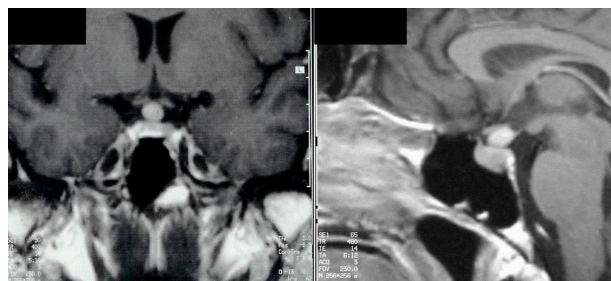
On the left, coronal T1-weighted, contrast-enhanced MR imaging showing a rounded mass located at the level of the pituitary stalk, over the pituitary gland, that appears intact; on the right, sagittal T1-weighted, contrast-enhanced MR imaging confirming the presence of a round mass located at the level of the pituitary stalk, over the pituitary gland, which in this plane seems enlarged in volume.
